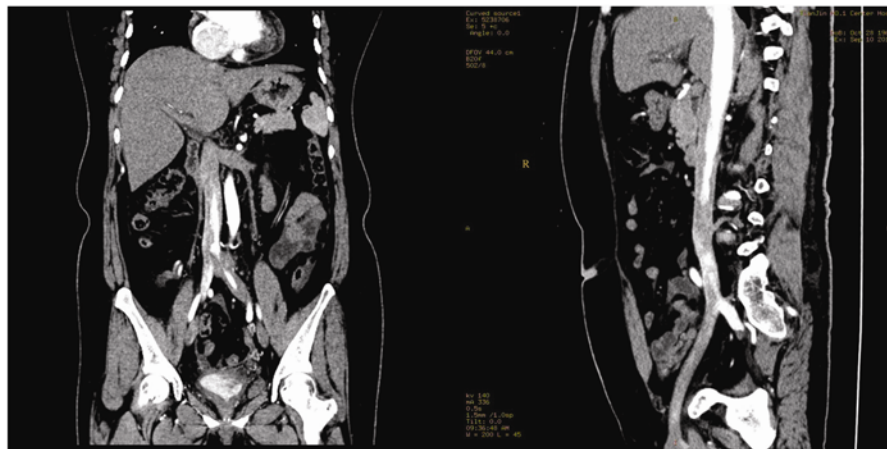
Enhanced CT scan revealed present of tumor in IVC
